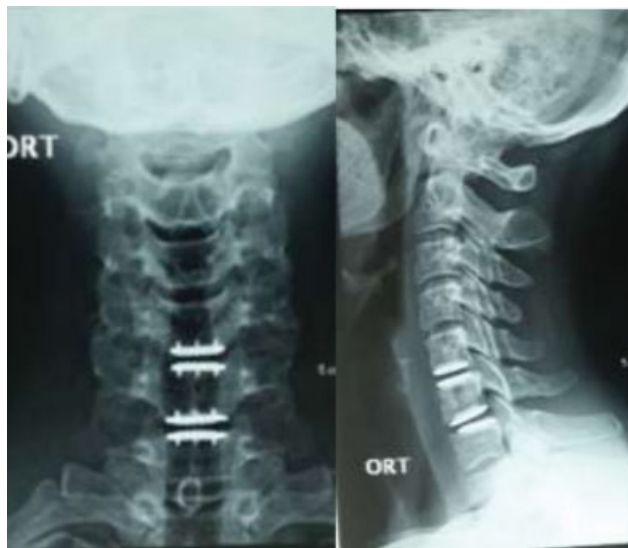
Cervical disc arthroplasty. (A) Radiography in anteroposterior incidence; (B) Profile radiography.
